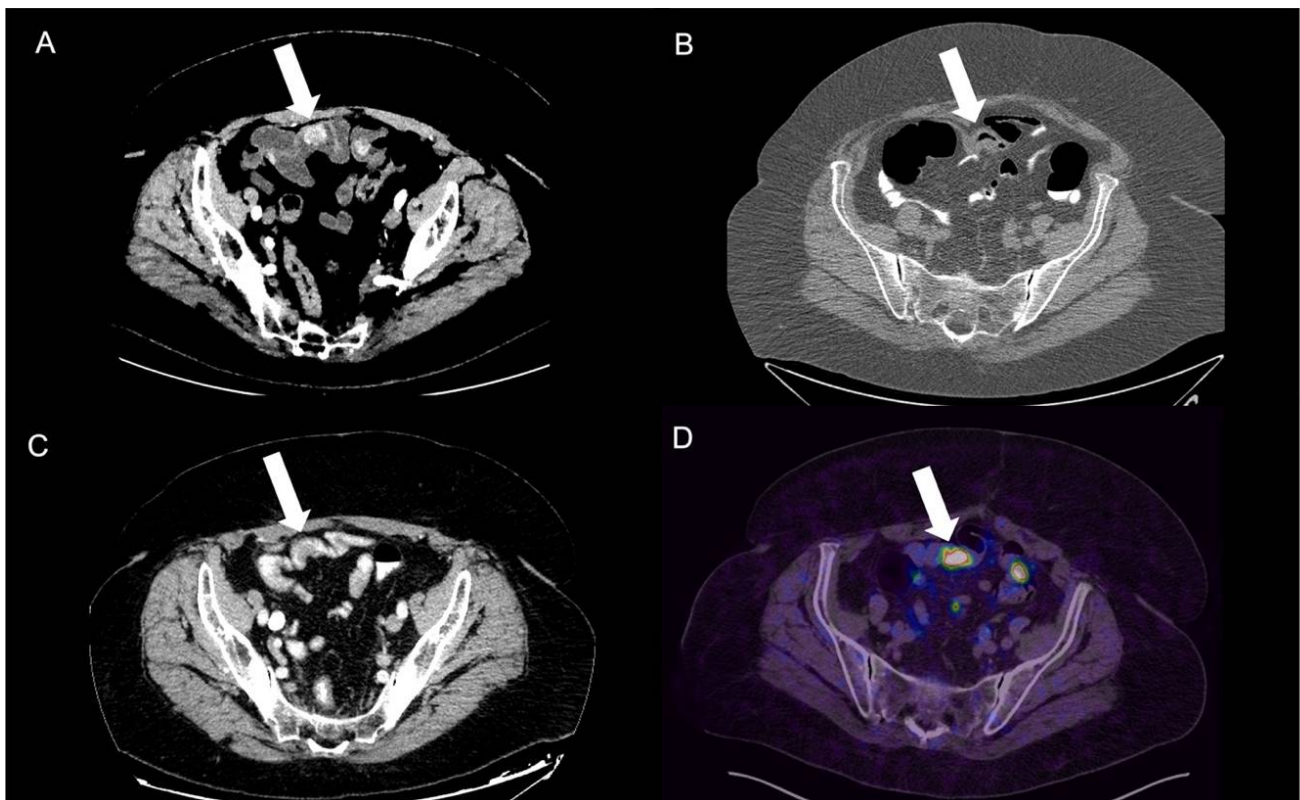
Ileal NEN tumors shown with different endoluminal contrasts and in PET-CT exam. The hypervascularized tumors are clearly different from normal bowel walls due to being highlighted in relation to endoluminal hypodense and hyperosmolar contrast media. The same patients previously had a colon CT performed, showing a slight air distension of lumen with minimal wall thickening that did not improve the tumor evidence, as well as a later contrast-enhanced CT with oral hyperosmolar iodinated contrast, which improved the intestinal lumen visualization but strongly limited the enhancement of tumors. PET/CT-68Gallium showed the same highly uptaking lesions, with the highest sensitivity compared to others, but this last one is not routinely performed without neuroendocrine suspicion being specific for highly probable or known NEN tumors. (A) CT-enterography, (B) virtual colonoscopy, (C) CECT with oral contrast, and (D) PET-⁶⁸Ga.
